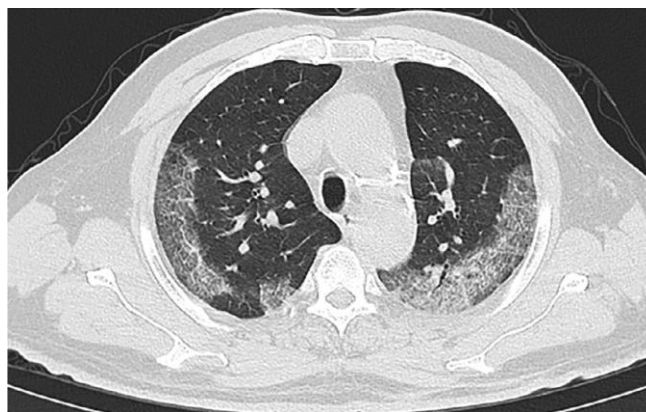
Typical chest CT findings compatible with COVID-19 pneumonia showing bilateral subpleural ground glass opacities (GGO).
